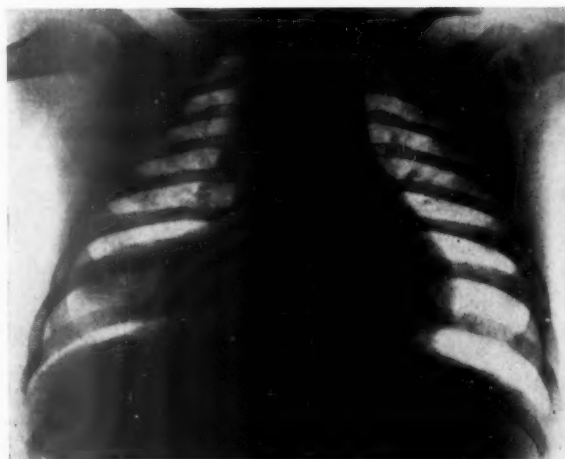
Radiograph showing right middle lobe collapse.
